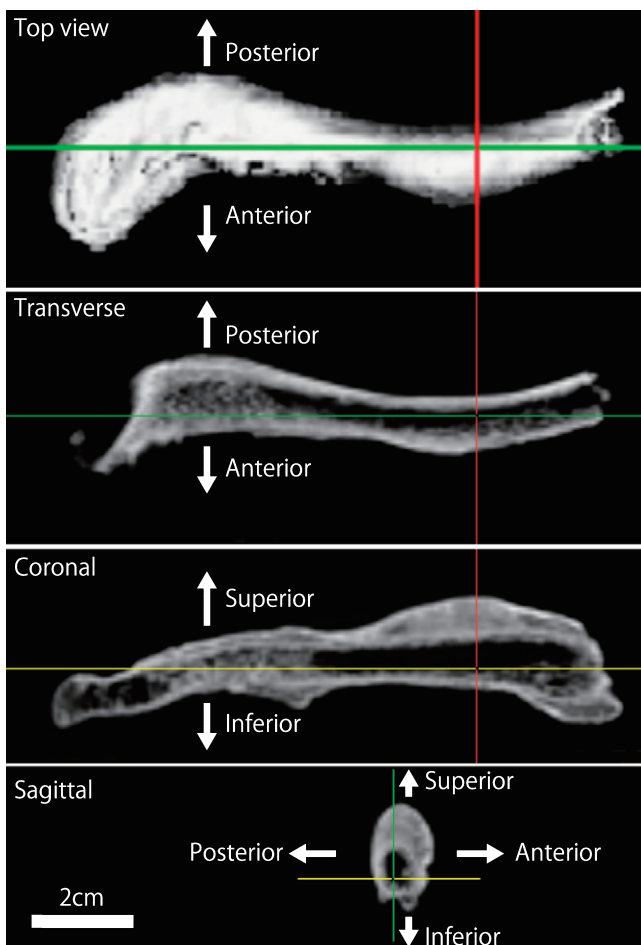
CT images of the right clavicle showed irregular cortical thickening, termed ‘grotesque periostitis.’
